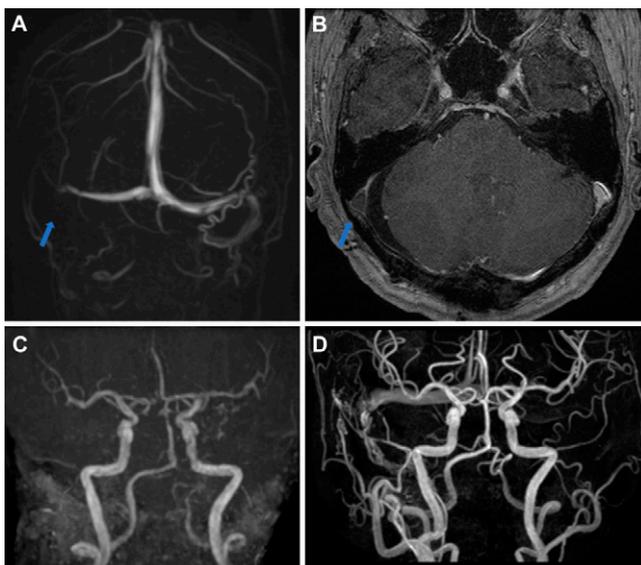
Postoperative imaging. A: Three-dimensional gadolinium-enhanced MR venography on postoperative day 1. The right SS (*blue arrow*) was occluded. B: Axial gadolinium-enhanced MRI on postoperative day 1. Thrombus (*blue arrow*) was identified in the right sigmoid sinus. C: Three-dimensional time-of-flight MRA on postoperative day 1. No obvious vascular abnormalities had been observed before surgery. D: Three-dimensional time-of-flight MRA at 47 months postoperatively. The right transverse sinus-SS and dilated abnormal arteries are visualized.
